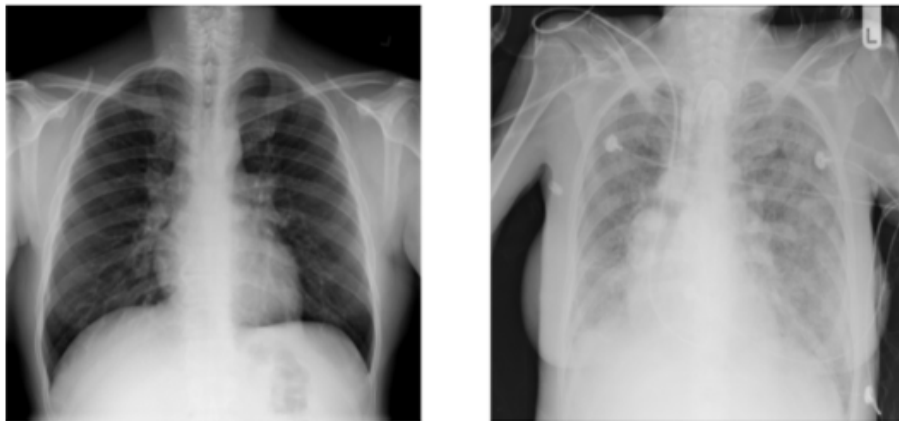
Normal (left) and abnormal (right) chest radiographs. Increased opacity suggests pneumonia.
